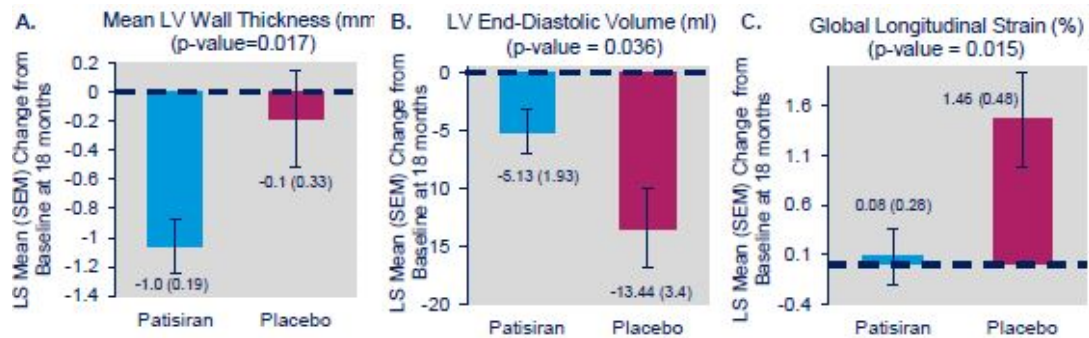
Echocardiographic parameters following 18 months of treatment with patisiran
